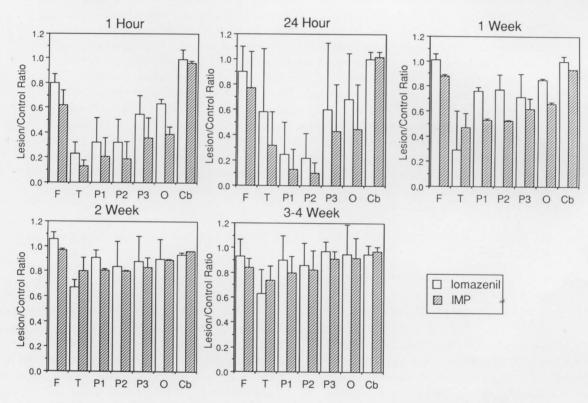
Serial changes of I-125 iomazenil (Iomazenil) and I-123 IMP (IMP) in each ROI. The values were expressed mean ratio values ± 1 s.d. of Iomazenil and IMP uptake in the lesioned hemisphere to that in contralateral hemisphere. Abbreviations on the x axis refer to the ROIs on MRI templates in Fig. 1.
